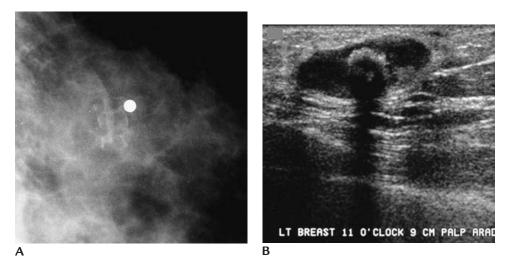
Portable catheter (port-a-cath) site changes. (A) Spot compression view of "lump" described by the patient. Metallic BB used to mark area of clinical concern. Low density calcifications possibly associated with surrounding radiolucent tissue. (B) Oval anechoic mass with well-circumscribed margins and posterior acoustic enhancement is imaged corresponding to palpable finding. Echogenic curvilinear focus internally with associated shadowing corresponding to one of the calcifications seen mammographically. The clinical, mammographic and sonographic findings correlate with the prior port-a-cath site. No further intervention is indicated. In most patients, these changes resolve spontaneously.
